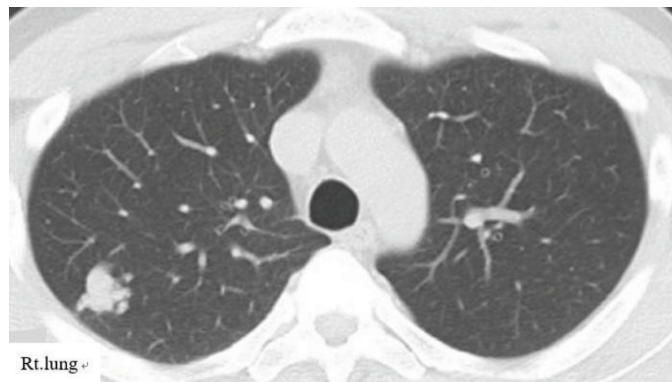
Enhanced chest computed tomography showing the lungs and mediastinum, revealing a large (>1 cm) nodule in the right lower lung
